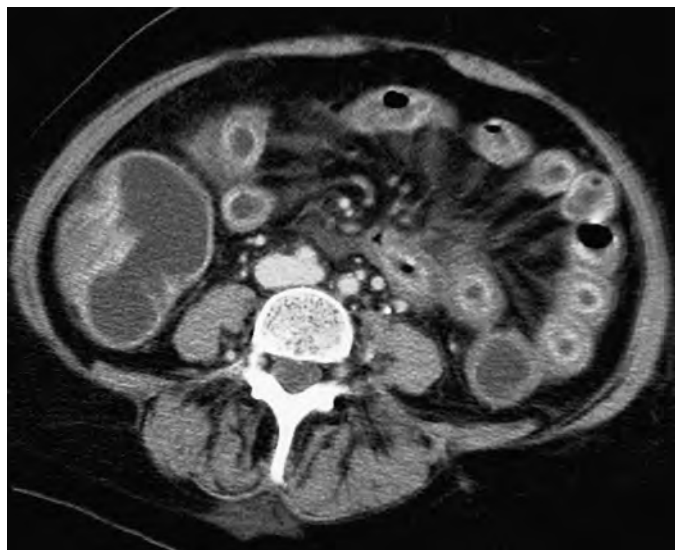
Graft-versus-host disease. Axial contrast-enhanced CT scan shows edema in the mesentery, small and large bowel wall thickening, and mucosal and serosal enhancement.
